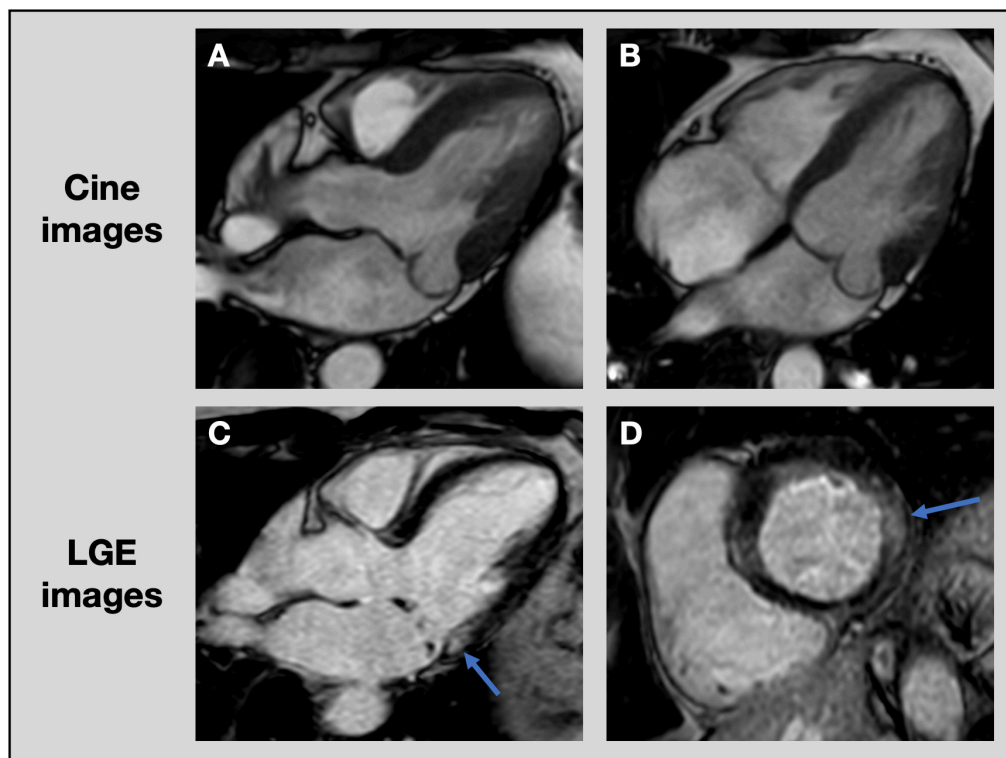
Assessment of focal fibrosis with cardiac magnetic resonance imaging. CMR cine images of patient with posterior leaflet prolapse on 3-chamber (A) and 4-chamber (B) views. Late gadolinium enhancement images show evidence of focal fibrosis in the basal inferolateral wall (blue arrows) on 3-chamber (C) and short axis (D) views. CMR, cardiac magnetic resonance imaging; LGE, late gadolinium enhancement.
